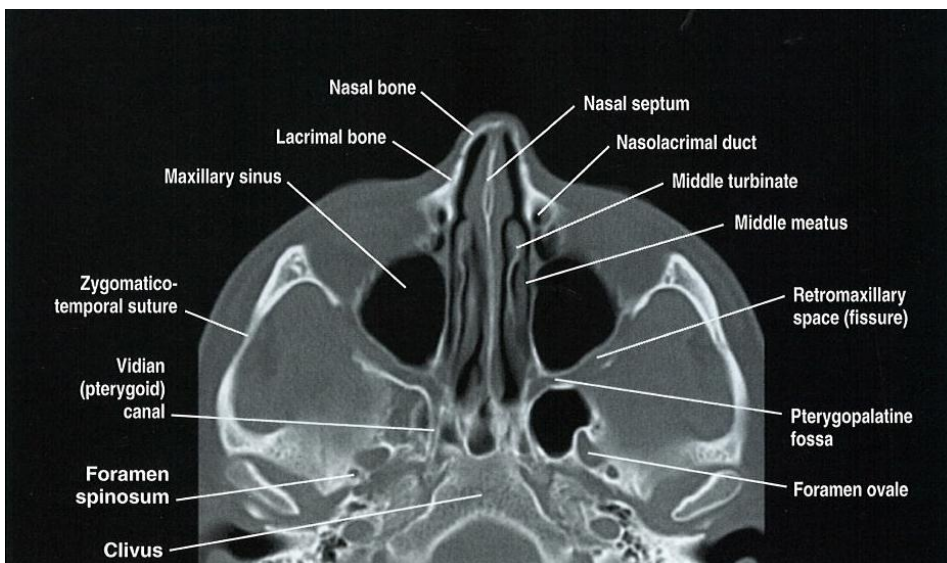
13 present the axial and coronal cross-sectional CT images of paranasal sinuses and nasal cavity. Three color scales in each cross-section, i.e. white, black, and gray, represent air, bone, and soft tissue areas, respectively. For example, oral cavity, nasal cavity, and paranasal sinuses are presented in black. Skull bones, orbit bones, facial bones, nasal bones (external nose, nasal septum, and nasal turbinates), and teeth can be seen as white. Soft tissues, e.g. brain, nasal mucosa, eye balls, nerves, tongue, etc., are shown in gray.
